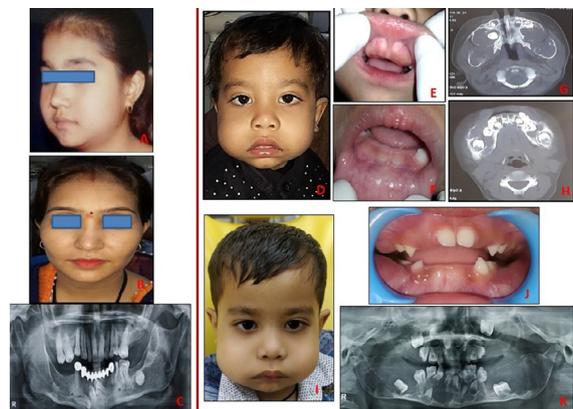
Case 3. (A) Extraoral photograph showing symmetric bilateral mandibular deformity in the patient's mother in her childhood. (B) Extraoral photograph of the patient's mother showing no evidence of any mandibular enlargement when she presented to us with her 3-year-old son. (C) Panoramic radiograph showing multiple osteolytic lesions involving the left mandibular ramus and the left and right mandibular body with multiple impacted teeth. (D) Extraoral photograph showing bilateral enlargement of the maxillae and the mandible at 3 years. (E), (F) Intraoral photographs showing unerupted primary teeth at 3 years. (G), (H) Axial computed tomography (CT) sections showing bilateral multilocular osteolytic lesions with cortical expansion involving the maxillae and the mandible at 3 years. (I) Extraoral photograph showing increase in mandibular and maxillary enlargement at 4.5 years. (J) Intraoral photographs showing eruption of primary teeth at 4.5 years and bony hard swelling in the bilateral mandibular posterior vestibular region. (K) Panoramic radiograph showing multiple osteolytic lesions involving the maxillae and the mandible, as well as the mandibular condyle bilaterally, with multiple impacted and displaced teeth at 4.5 years.
